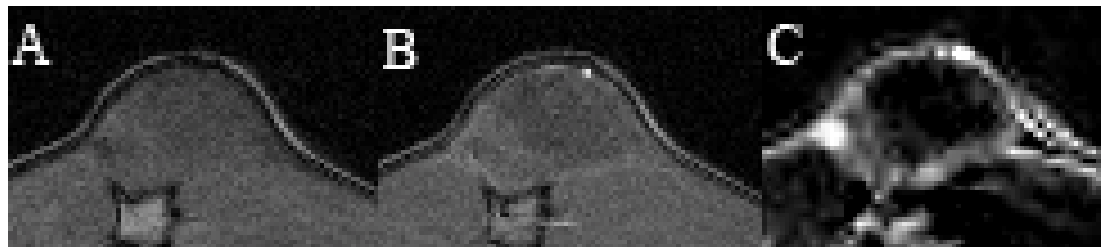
A & B T1-weighted gradient echo before (A) and after (B) galbumin administration. C shows signal enhancement parameter map from DCEMRI acquired during Galbumin administration. Note areas of peripheral enhancement.
